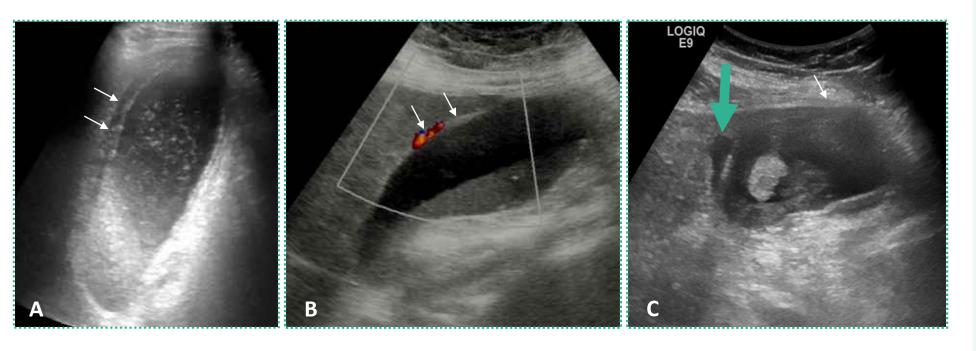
Ultrasound images – Acute cholecystitis in three different patients
